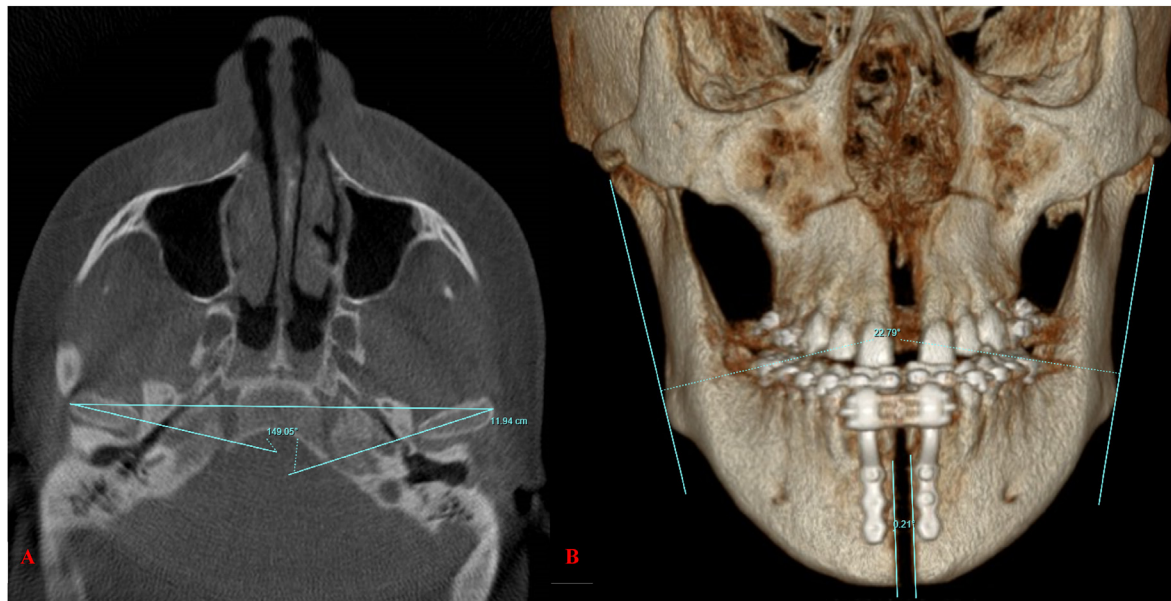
Skeletal measurements regarding bone-borne vs tooth-borne MMD using axial CBCT slices and 3D skeletal view at T1, T2 and T3. A: ICOND, ICONA; B: RA, DGAPA (only at T2).
